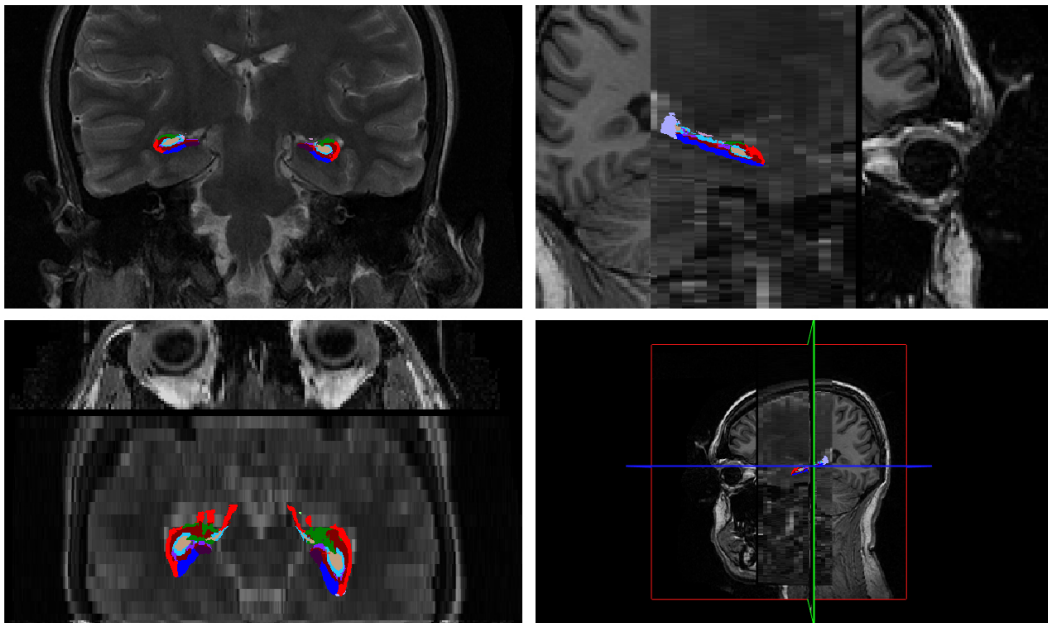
T2-weighted image from the data set, overlapped to the T1-weighted image of the same subject.
